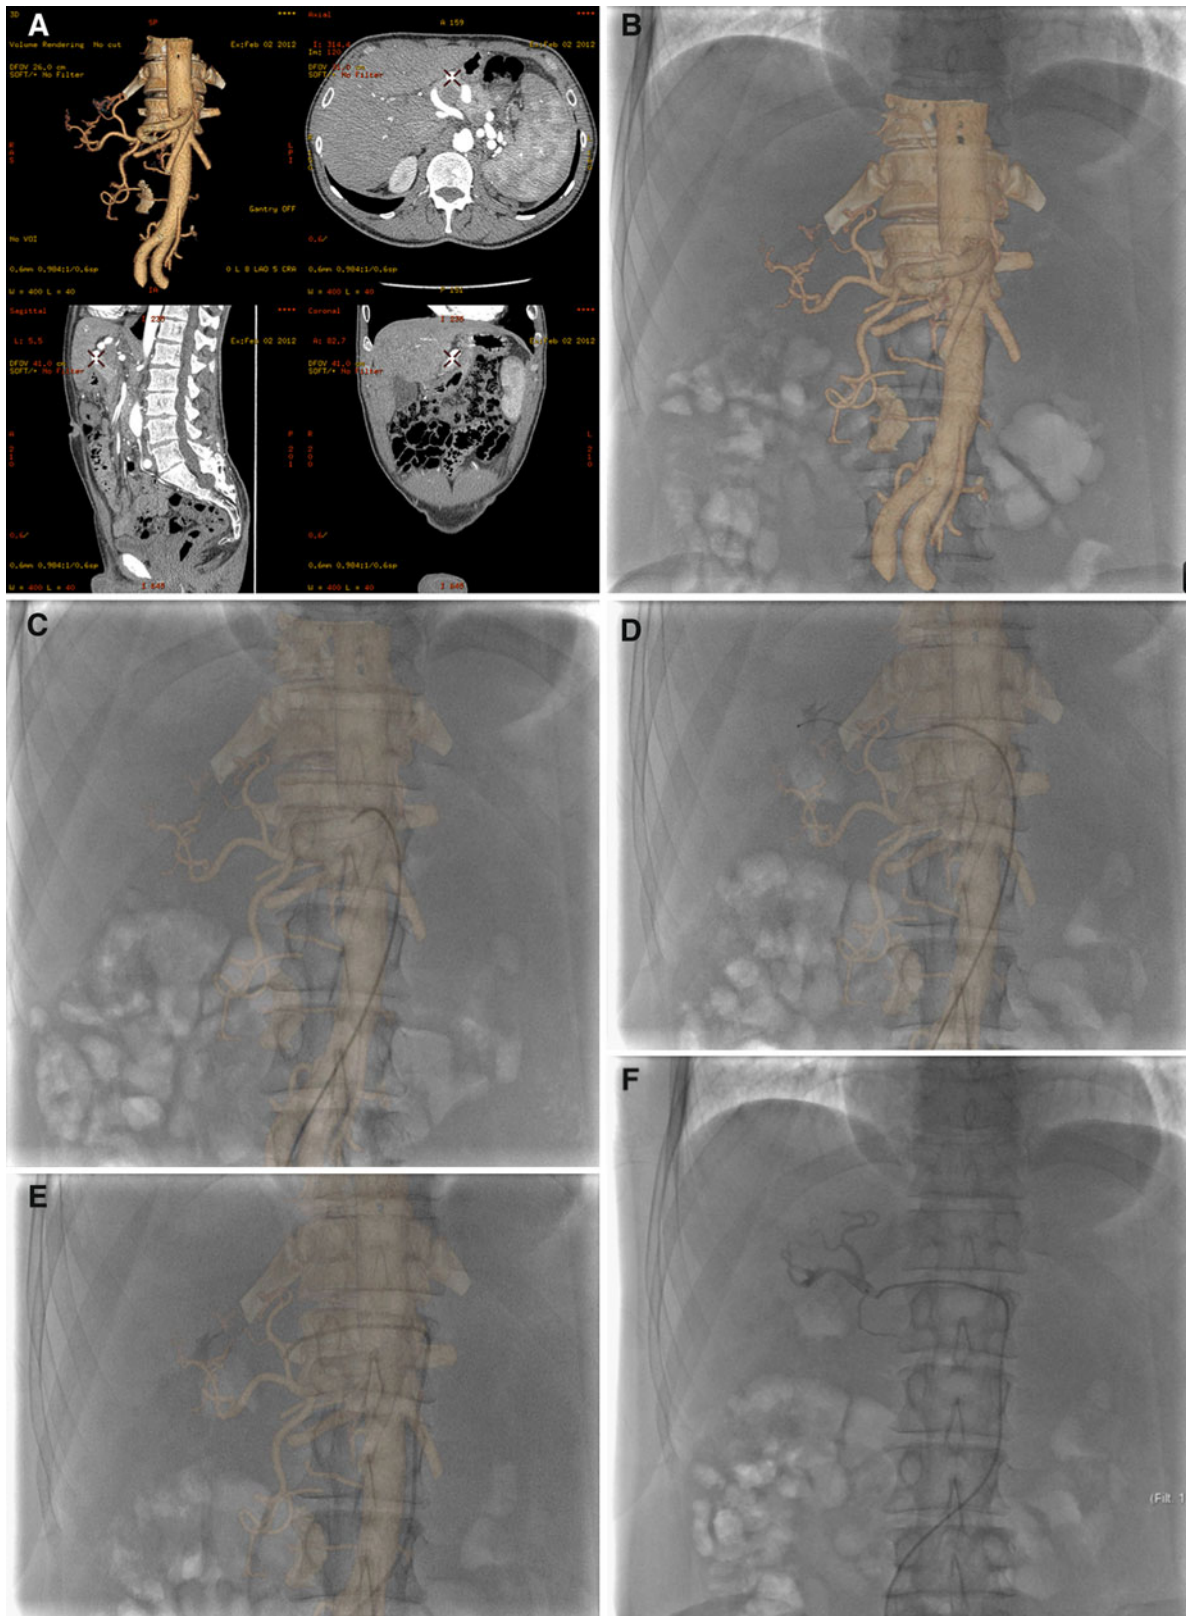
Early arterial phase CT images are postprocessed on an independent workstation by semiautomatic segmentation, obtaining the VR model of abdominal aorta and splanchnic arteries (A). The 3D model is then manually registered to the real-time fluoroscopic image
